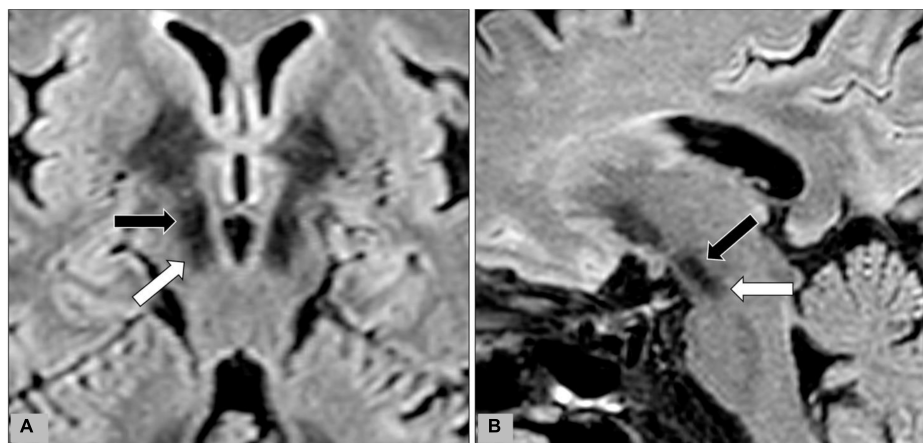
During data-postprocessing, we selected the level of axial image with the optimal visualization of subthalamic nuclei (black arrows) after a review of the T2WI, FLAIR, and SWI images. Oblique coronal (A) and sagittal (B) reformation images were rechecked to ensure that the substantia nigra (white arrow) was not covered on the selected image.
